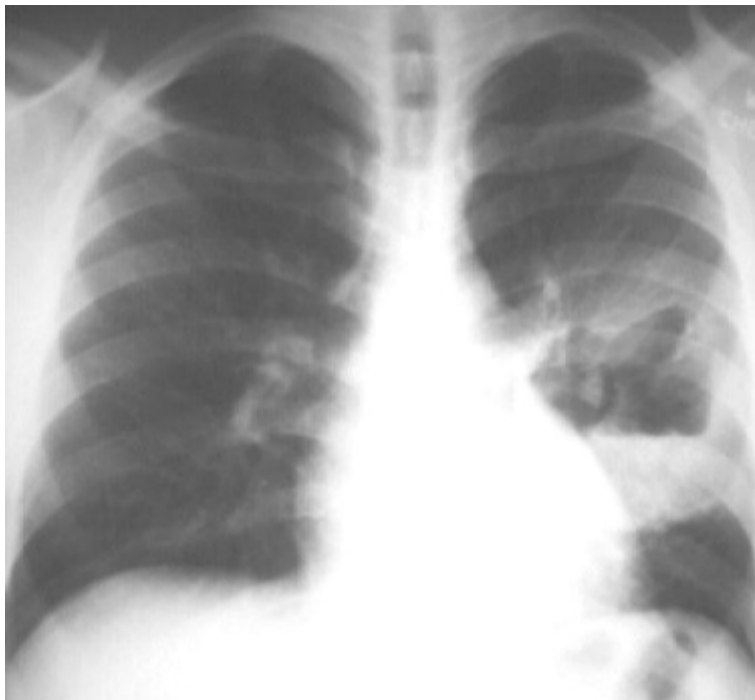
Chest x-ray of lung abscess
